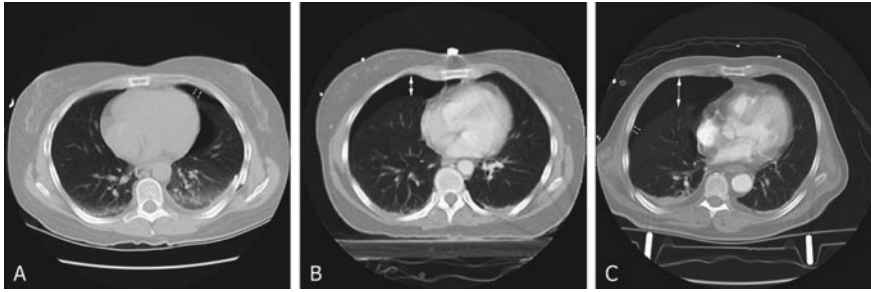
The progression of lateral edge of intrapleural air is shown on these CT scan images, demonstrating the greater the pneumothorax, the more lateral is the lung point. However, in large pneumothorax, the laterality of the lung point may fail in indicating the progression of pneumothorax volume (from Michael Blaivas, Matthew Lyon, Sandeep Duggal, Prospective Comparison of Supine Chest Radiography and Bedside Ultrasound for the Diagnosis of Traumatic Pneumothorax, *Acad Emerg Med.* 2005 Sep;12(9):844–9)
